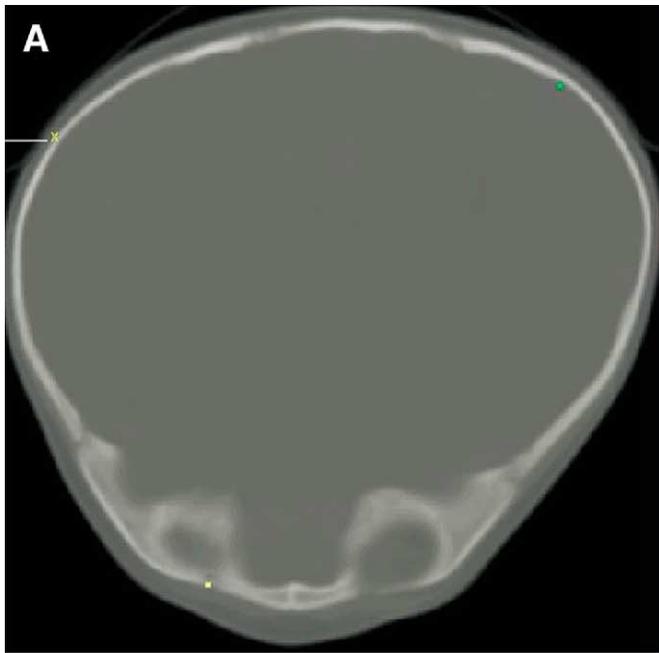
Head CT (bone windows) showing posterior plagiocephaly. A, Axial view. B, Sagittal view.
